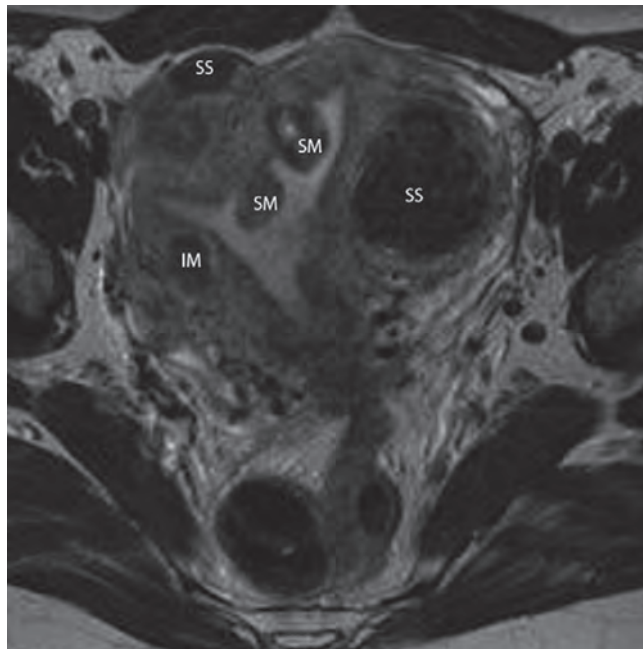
Coronal T2-weighted MRI shows multiple uterine submucosal (SM), subserosal (SS), and intramural (IM) fibroids. (From Griffin Y, Sudigali V, Jacques A. Radiology of benign disorders of menstruation. *Semin Ultrasound CT MR.* 2010;31[5]:414–432.)
